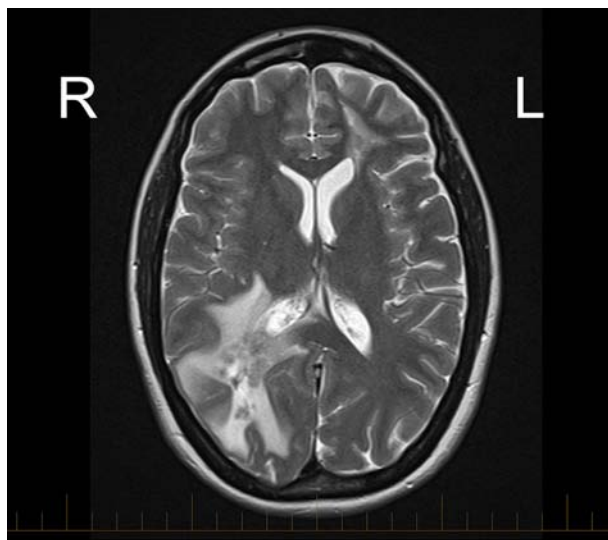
Cerebral magnetic resonance imaging (T2, axial) demonstrating multiple right (R) parietal microabscesses as well as a left (L) frontal lesion suggesting previous infection.
